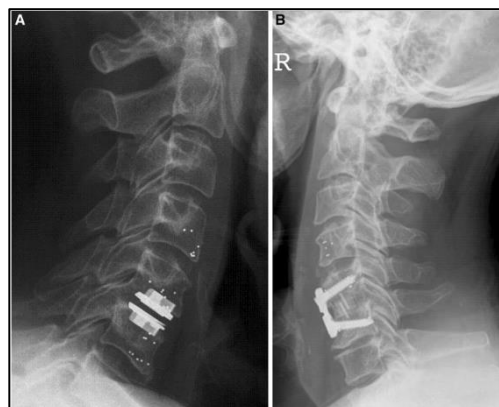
Lateral X-ray of a cervical spine showing the tantalum markers of the vertebral body C4, C5 and C6. a - Incorporated tantalum markers after disc replacement. b - The same with titanium plate fixation. Image from the study of Nabhan A. et al (2011).
